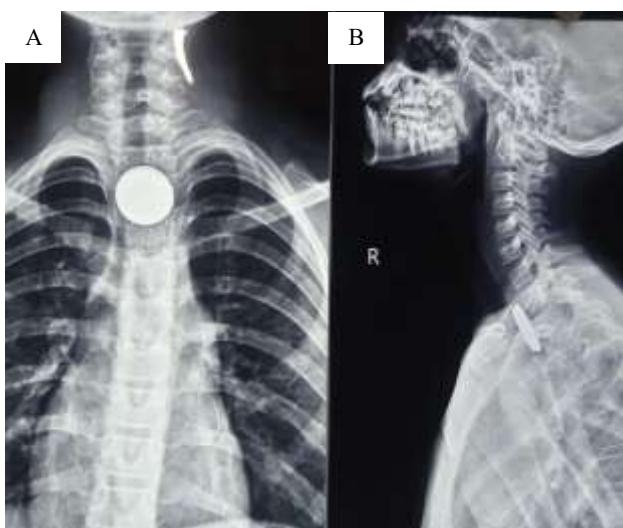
(A and B): Orthogonal plain films of case 2.
